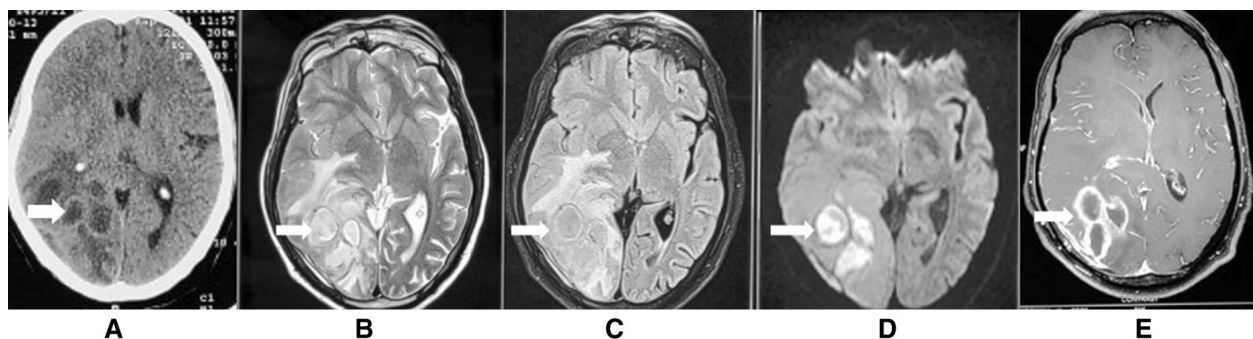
A NCCT brain showing ill-defined hypodense lesions in right occipital location (arrow). B T2W and C FLAIR MR images showing T2 hyperintense lesions with surrounding vasogenic edema not suppressed in FLAIR images (arrow) D DWI image showing diffusion restriction (arrow). Post-contrast images E showing peripherally enhancing lesions with adjacent pachymeningeal enhancement (arrow)—suggestive of brain abscesses with pachymeningitis
